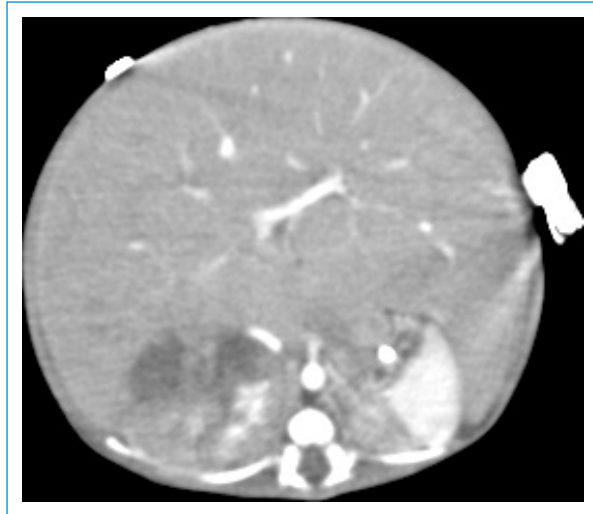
Abdominal CT with contrast performed on the fifth day of life, showing liver metastasis.
